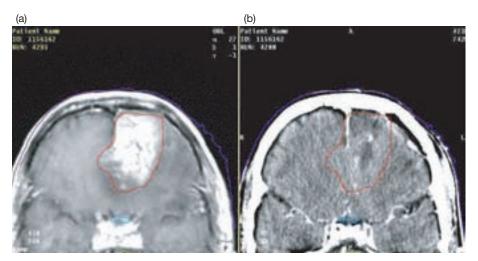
(a) An MR image of a patient with a brain tumour. The target has been outlined and the result was superimposed on the patient's CT scan (b). Note that the particular target is clearly seen on the MR image but only portions of it are observed on the CT scan.
